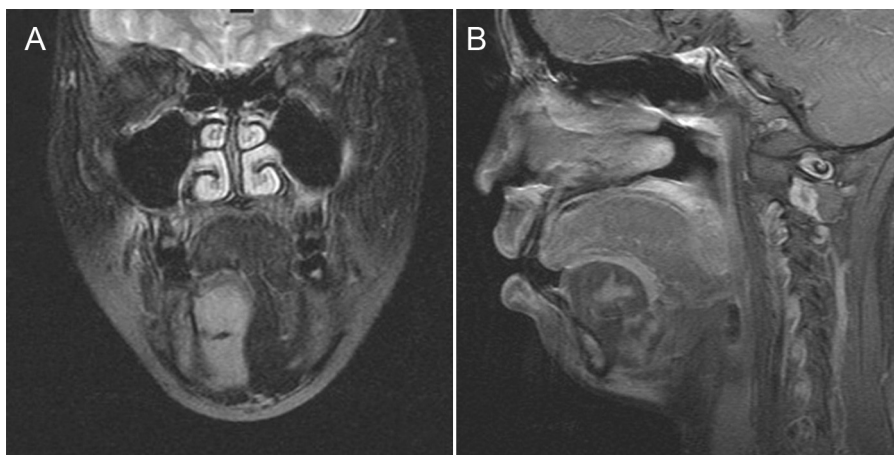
Preoperative magnetic resonance imaging. (A) The mass showed high signal intensity on T2-weighted images and (B) low signal intensity on diffusion weighted images.
